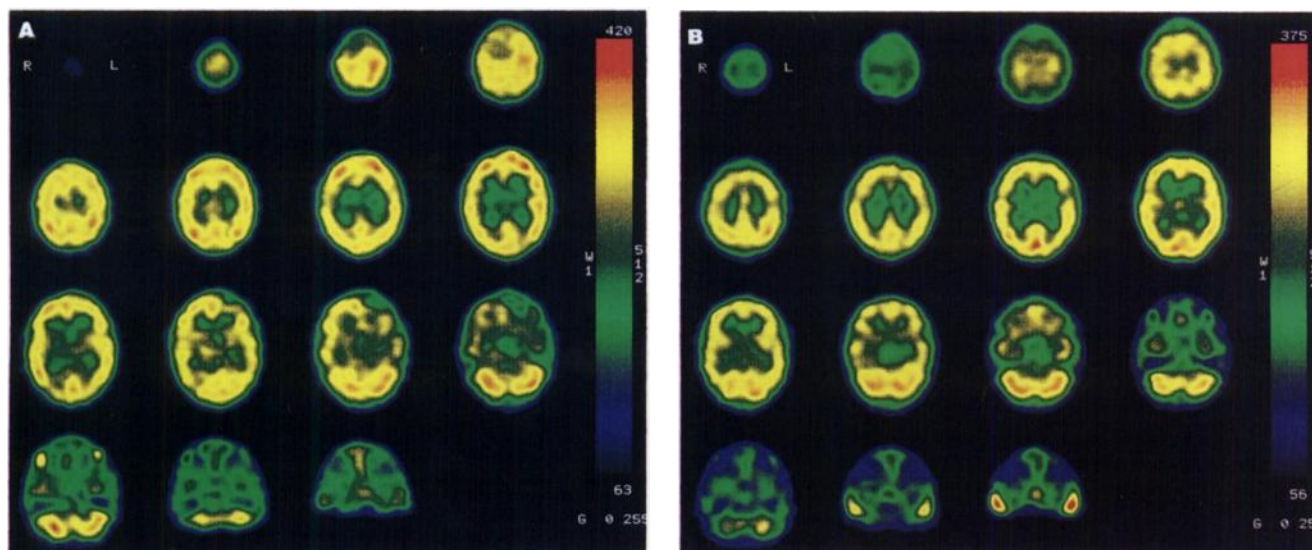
A 22-yr-old male who had suffered a moderate head trauma during a car accident. The initial ^{99m}Tc -HMPAO SPECT study (A), performed 2 days after the trauma, shows a large region of markedly decreased perfusion in the left inferofrontal cortex and a small region of markedly decreased tracer uptake in the right frontoparietal area (score of perfusion abnormality = 4). Three months later, clinical evaluation as well as repeat SPECT (B) were completely normal.
